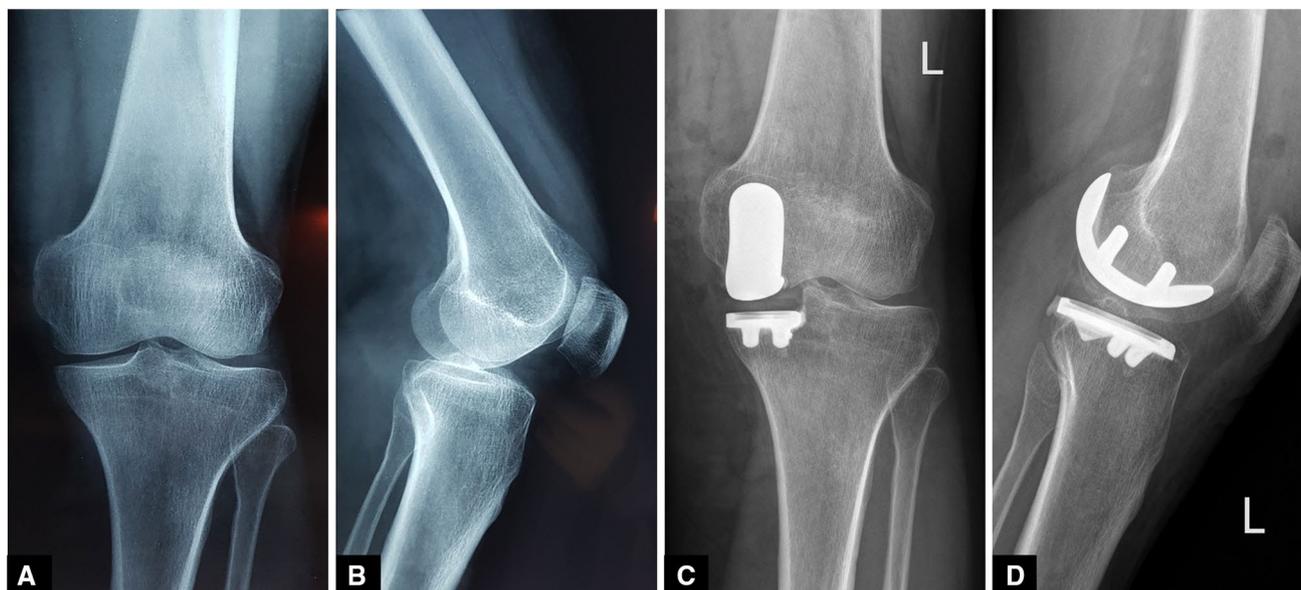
a Anteroposterior and b lateral radiograph in a 70-year-old woman with isolated arthritis of the medial compartment of the left knee, before surgery. c Anteroposterior and d lateral radiograph after
